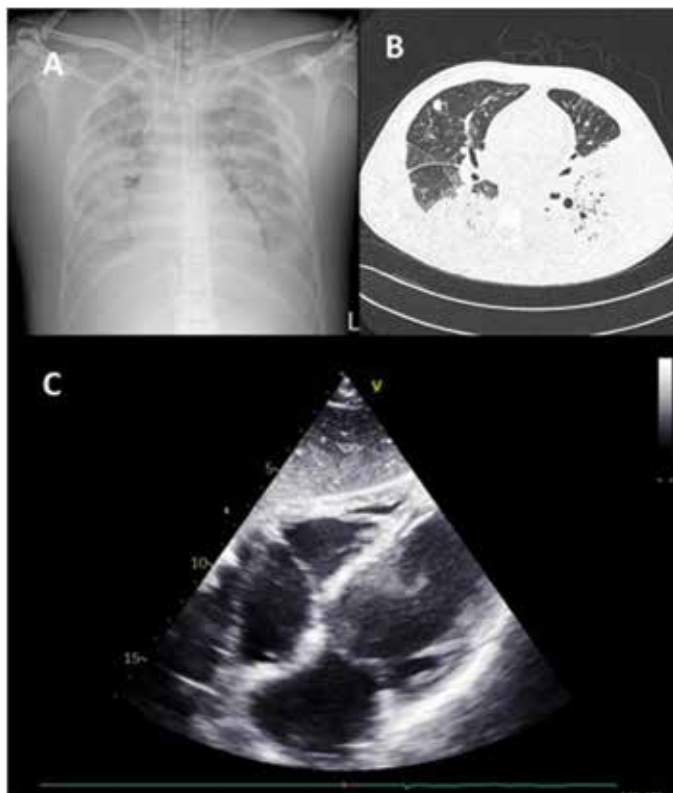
Imaging methods after admission: A) Chest X-ray after VA ECMO placement showing bilateral extensive confluent, homogeneous infiltrates of the lung parenchyma; B) Computed tomography showing extensive zones of consolidation in the lower lobes of the lungs and large zone of destruction of left lower lung lobe; C) Echocardiography (subcostal view) showing thrombus formation in the left ventricle.
